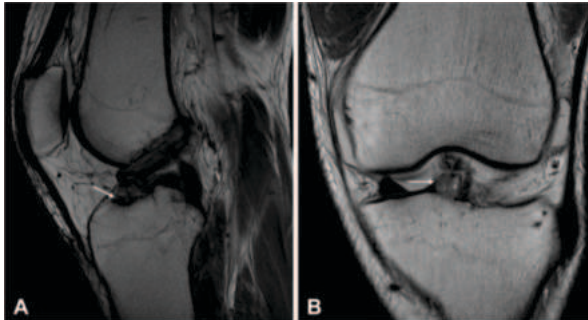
A type V soft tissue avulsion tear (arrow) is seen on the (A) sagittal T1-weighted view and (B) coronal T1-weighted view.
